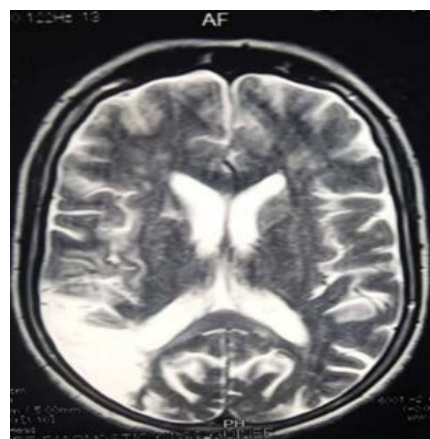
MRI cerebral sequence T2 axial slice which shows a right temporo-occipital hypersignal with widening of the cortical furrows and arachnoid spaces.
